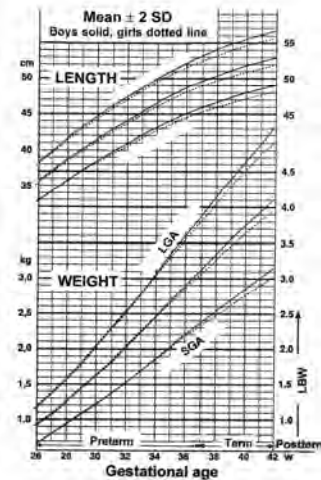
Birth length and birth weight curves according to ultrasonically estimated fetal weights at different gestational ages⁹.
